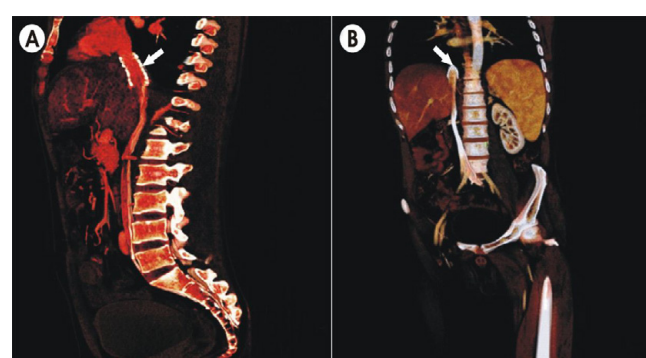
Follow-up computed tomography images. (A) Sagittal and (B) Coronal sections showing well placed stent (arrow) across occluded segment of the inferior vena cava.
